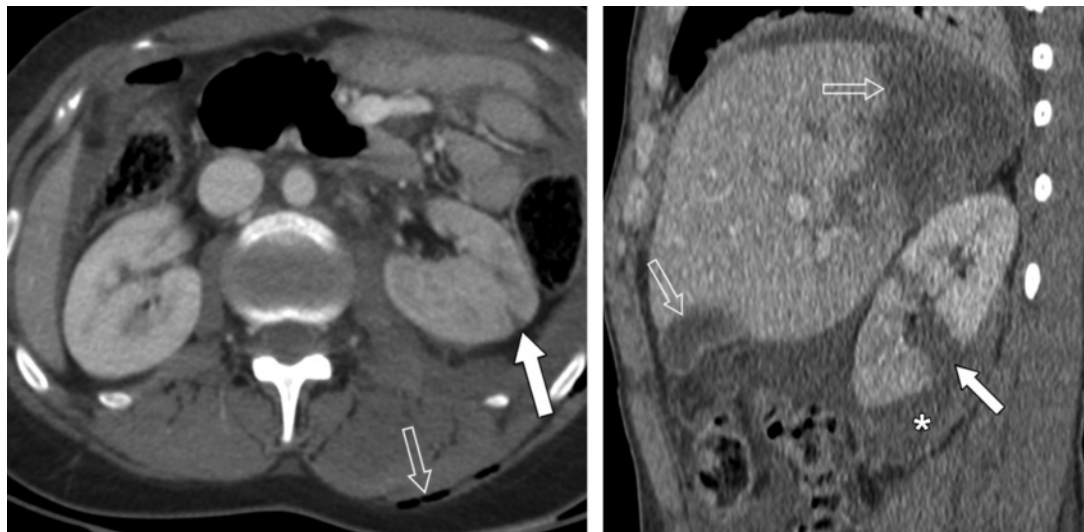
Left perinephric hematoma (grade II injury) in a 60-year-old man who sustained blunt abdominal trauma in a motor vehicle accident. CT scan shows a left perinephric hematoma (solid arrow). A left adrenal hematoma and a deep splenic laceration with perisplenic hematoma and active bleeding were also found. Open arrow indicates a nasogastric tube.
